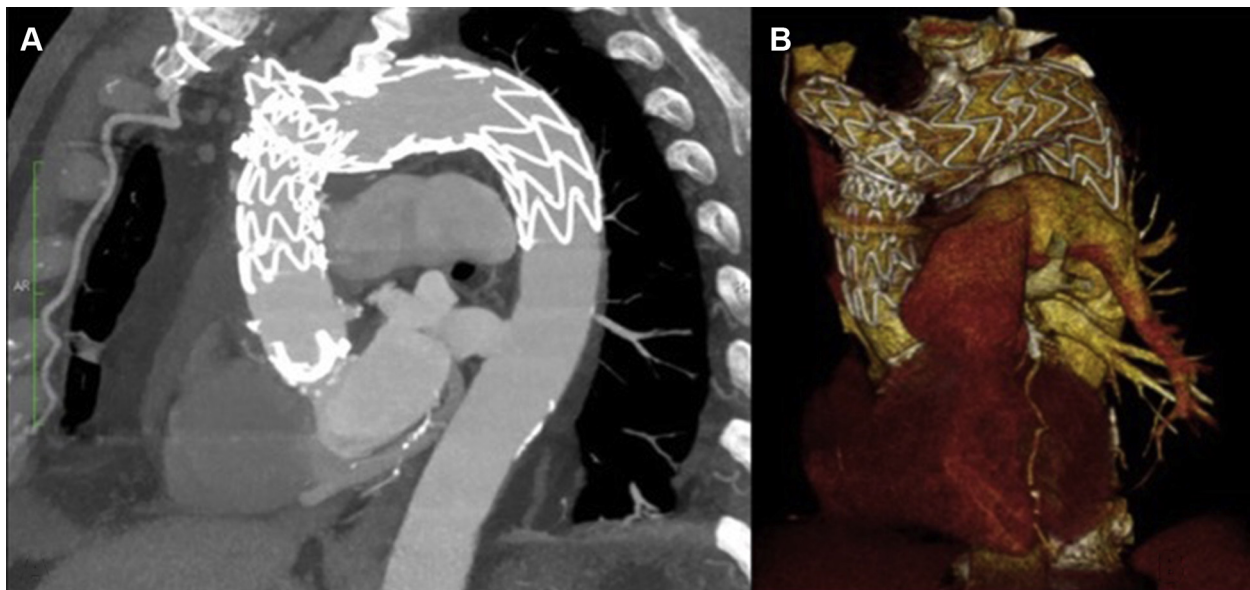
Six-month computed tomography angiogram control. (A) Lateral view shows good positioning of the aortic arch endograft with complete exclusion of the pseudoaneurysm. (B) Three-dimensional reconstruction shows complete aortic arch exclusion and side branch in innominate artery.
